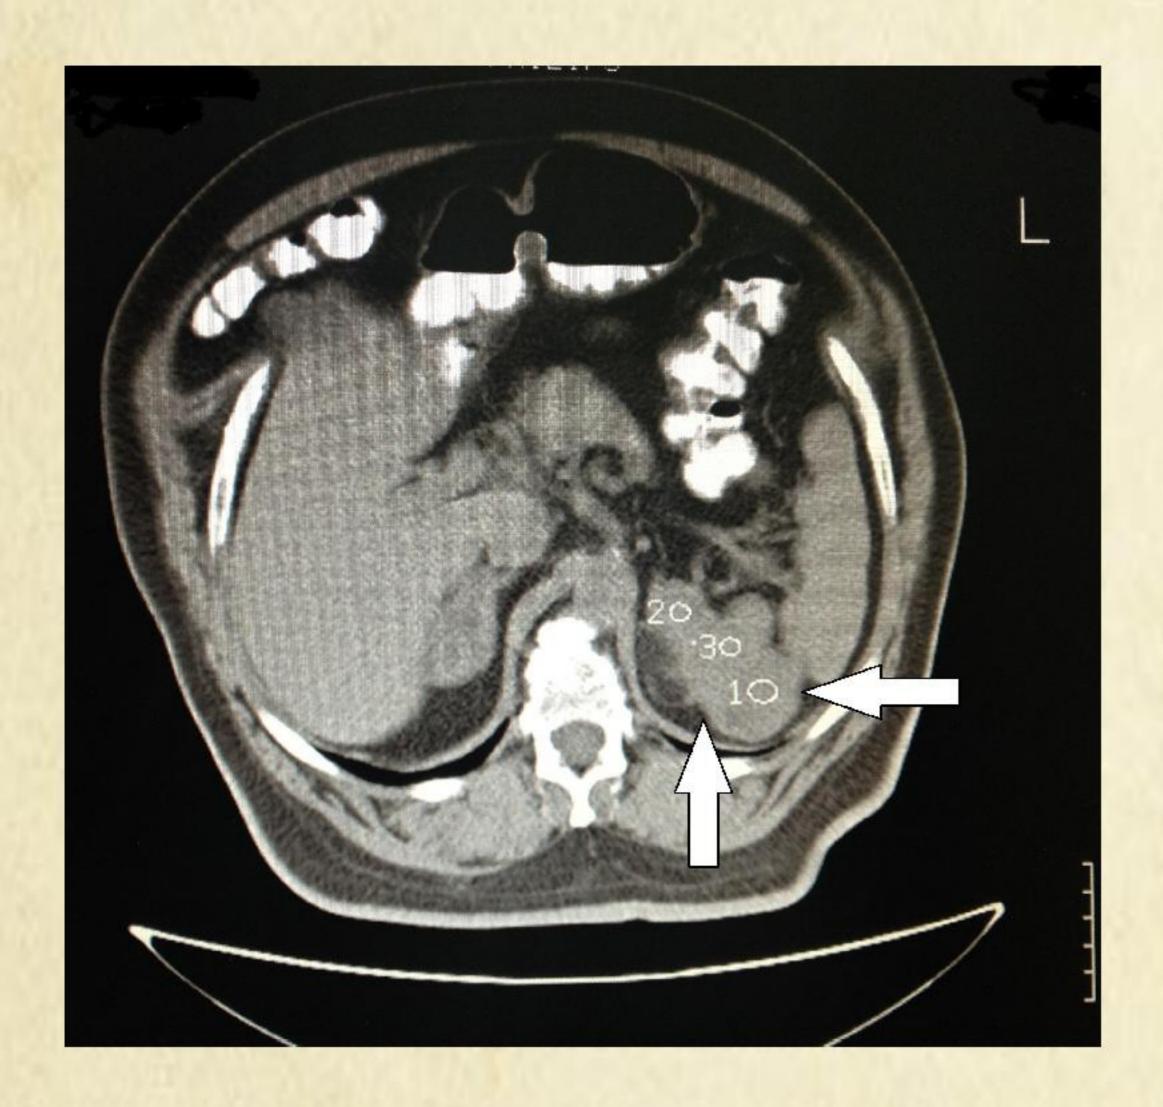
Adrenal CT of the patient. The left adrenal mass is seen. HU 1-3, >60% washout at 15'
